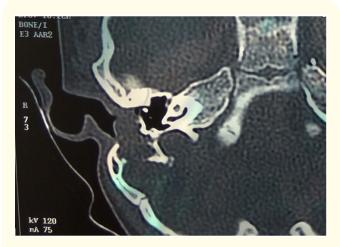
HRCT image showing soft tissue in right mastoid tip cells with posterior canal wall dehiscence.
